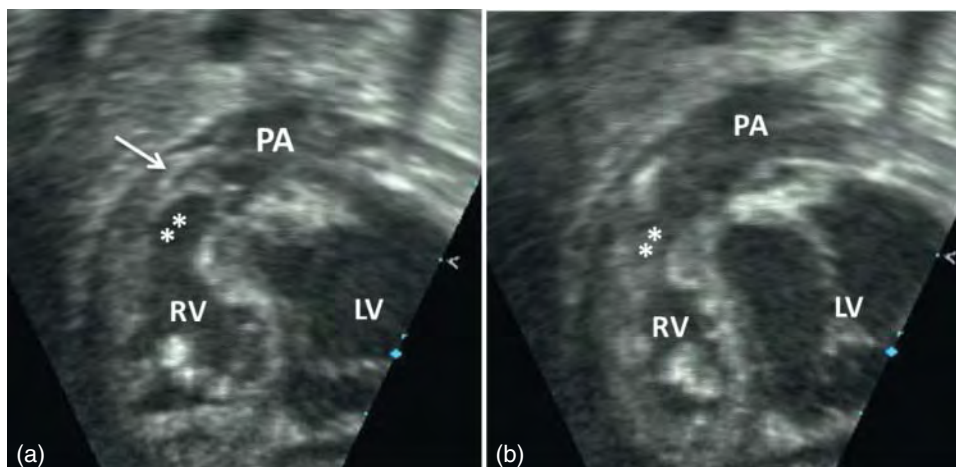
Transthoracic echocardiogram following successful balloon pulmonary valvuloplasty. (a) In ventricular diastole, note the significant degree of right ventricular hypertrophy, particularly in the region of the conal septum (infundibular region), which appears thickened but unobstructed (asterisks) at this point in the cardiac cycle. (b) During ventricular systole, the appearance of severe dynamic subvalve (infundibular) obstruction becomes evident (asterisks) as the hypertrophic infundibular muscle causes near obliteration of the outflow tract despite good systolic opening of the pulmonary valve leaflets.
